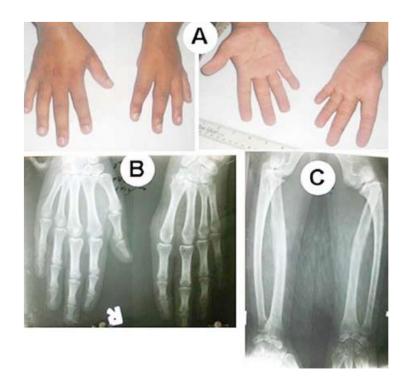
Phenotypic and radiographic presentation in case XIV.(A): Dorsal and ventral view of hands (B): Radiographs of hands, (C): Radiographs of forearms.
